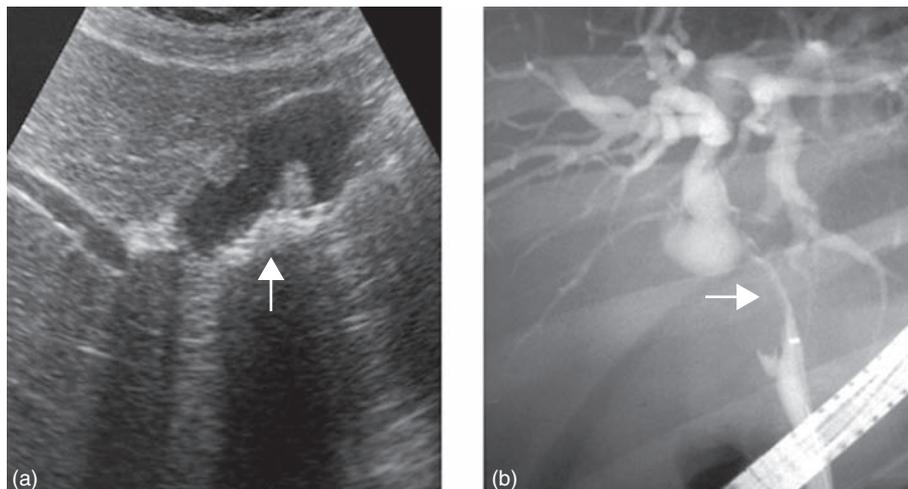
Sonographic and cholangiographic appearance of gallbladder cancer. (a) A coronal ultrasound image through the gallbladder shows asymmetric thickening of the gallbladder wall (arrow) with a mass projecting into the gallbladder lumen. (b) An endoscopic retrograde cholangiogram of locally advanced gallbladder cancer shows narrowing of the mid-bile duct, non-filling of the cystic duct, and proximal bile duct dilatation.
